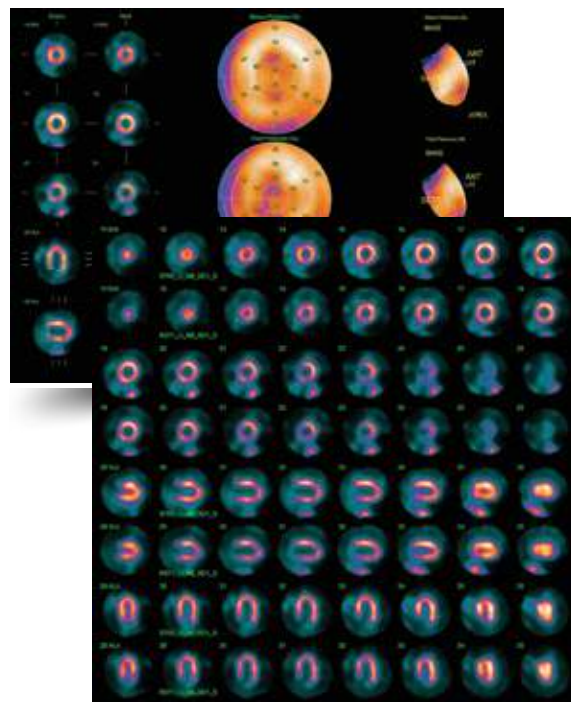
Image Gallery: Digital SPECT
